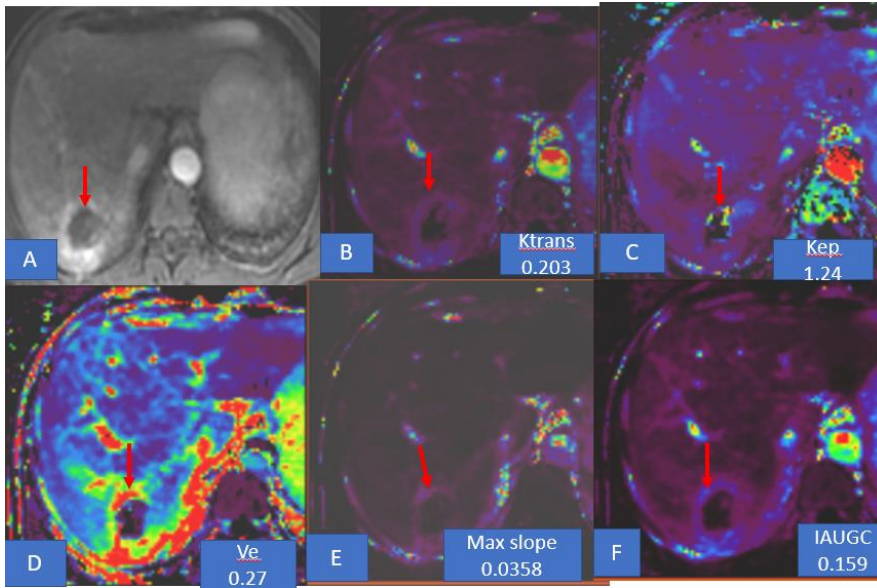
After TACE MR perfusion images. A.DCE image showing complete necrosis with no enhancement in the lesion in seg VI(arrow), B – F colour maps of various MR perfusion parameters showing the lesion(arrow) with increase in postTACE MRI values of K trans,, Kep, Max slope and IAUGC with no significant increase in Ve indicating false positive residual lesion. B. Ktrans colour map, C. Kep colour map, D. Ve colour map, E. max slope colour map, E. IAUGC colour map
